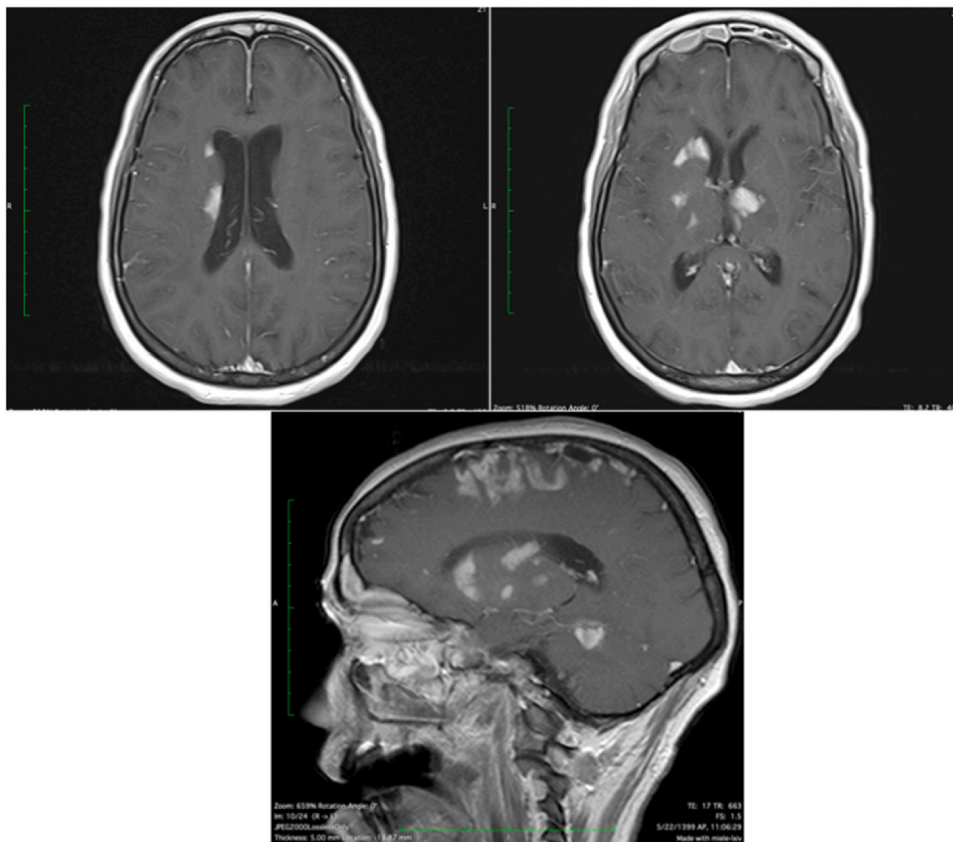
T1-weighted brain MRI with gadolinium: Diffuse leptomeningeal and patchy bilateral basal ganglia and cerebral peduncles enhancement. Bilateral frontal gyral enhancement.
